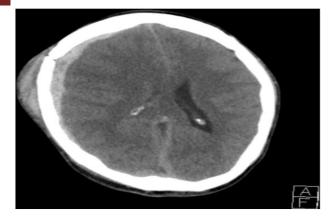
2 This plane CT scan a fracture inside the right transient bone with overlying cutaneous haematoma. Subarachnoid blood is exhibited by the hyper attenuating material inside the lateral ventricles.
